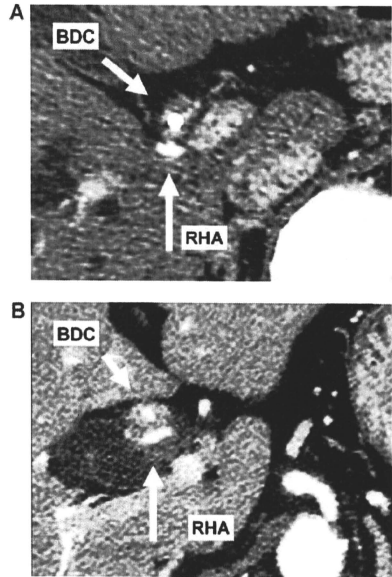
Representative figure of CT-A. The figure showed the tumor (BDC) closely attached to the right hepatic artery (RHA). A: CT-A1, B: CT-A2.
